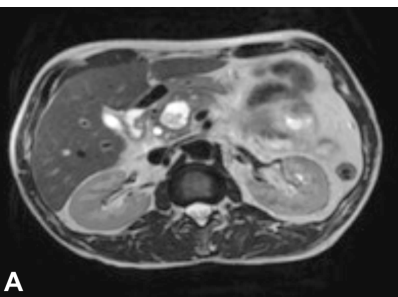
(A and B) MRI examination confirming cystic pancreatic mass and portal vein thrombosis (day 6 from admission). MRI: Magnetic resonance imaging.
